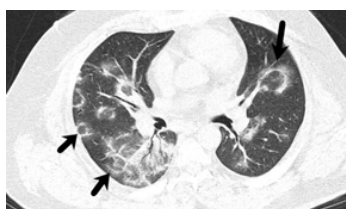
Axial nonenhanced CT lung window section of 43 year old male showing Reverse halo aka Atoll sign (arrow) i.e. ground-glass opacity surrounded by denser consolidation of crescentic shape or complete ring.
